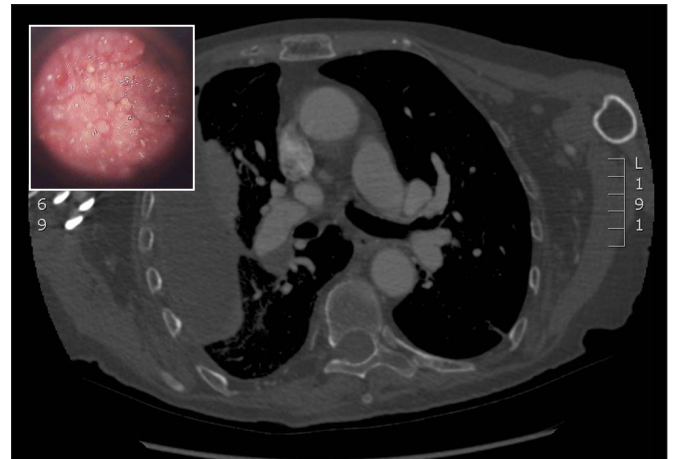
CT scan and image via medical thoracoscopy of patient with mesothelioma.
